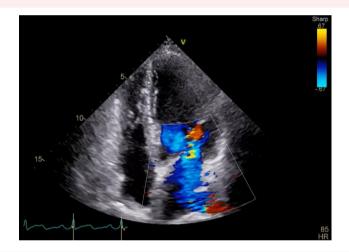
Initial transthoracic echocardiography showing moderate-to-severe mitral regurgitation, ruptured chordae tendineae attached to the P2 segment, and a vegetation (arrows).
